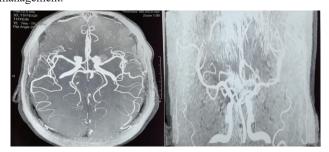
Image I Cerebral MRI showing a saccular aneurysm of the left internal carotid artery, which is totally thrombosed.
